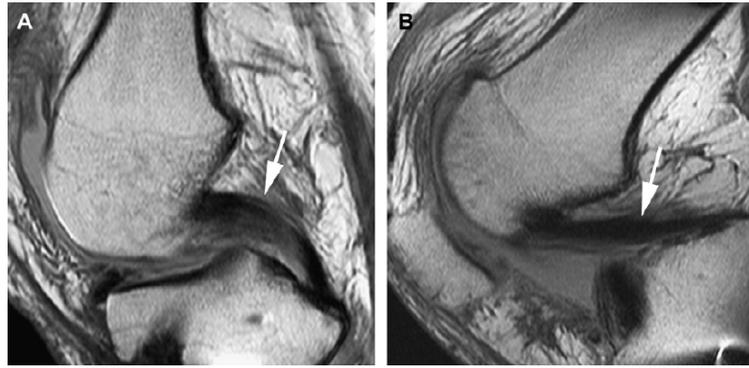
Normal PCL on sagittal proton density MR imaging in extension and flexion.
